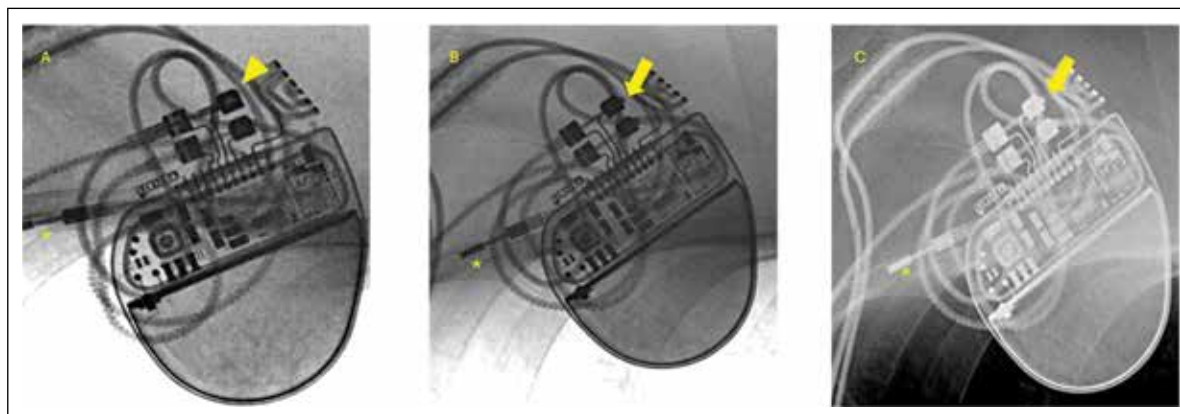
This image series was that of the patient whose device interrogation, showed high atrial lead impedance ($>1500 \Omega$) with loss of capture. On interrogation, chest radiograph showed atrial lead was not properly screwed in. This can be identified as no projection of the proximal part of the lead beyond the screw (arrowhead) which can be compared with the ventricular lead counterpart (A). The proximal portion of the lead seen projecting out of the screw after repositioning (arrow) (B). Note another abandoned, capped and buried lead (C) underneath the pulse generator (*).
